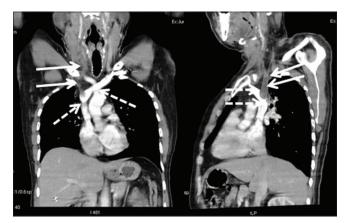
Coronal and sagittal contrast computed tomography chest showing hypodense filling defect in the right internal jugular vein reduced in extent with tiny calcifications, suggesting chronic thrombus (arrows), and patent left innominate vein filled with contrast streaking past the thrombus into superior vena cava (dotted arrows)
